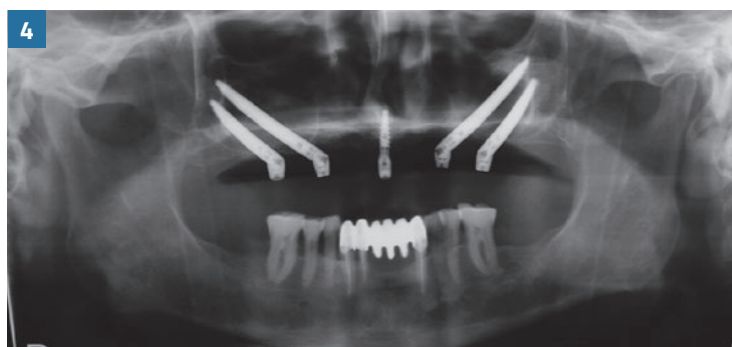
Post surgery panoramic radiograph
